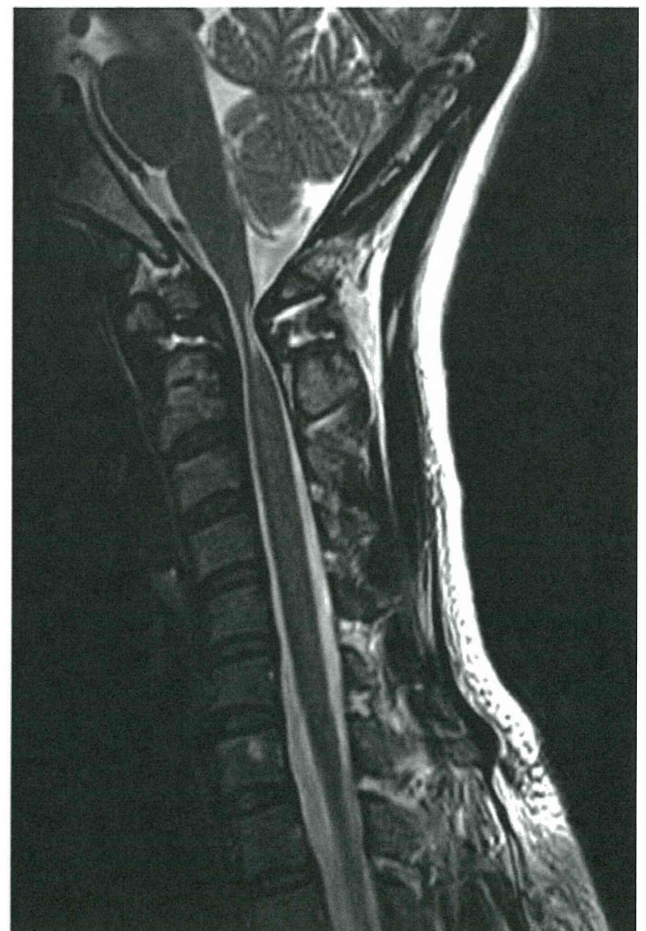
T2-weighted magnetic resonance image demonstrating cord compression with intramedullary high signal intensity change.
